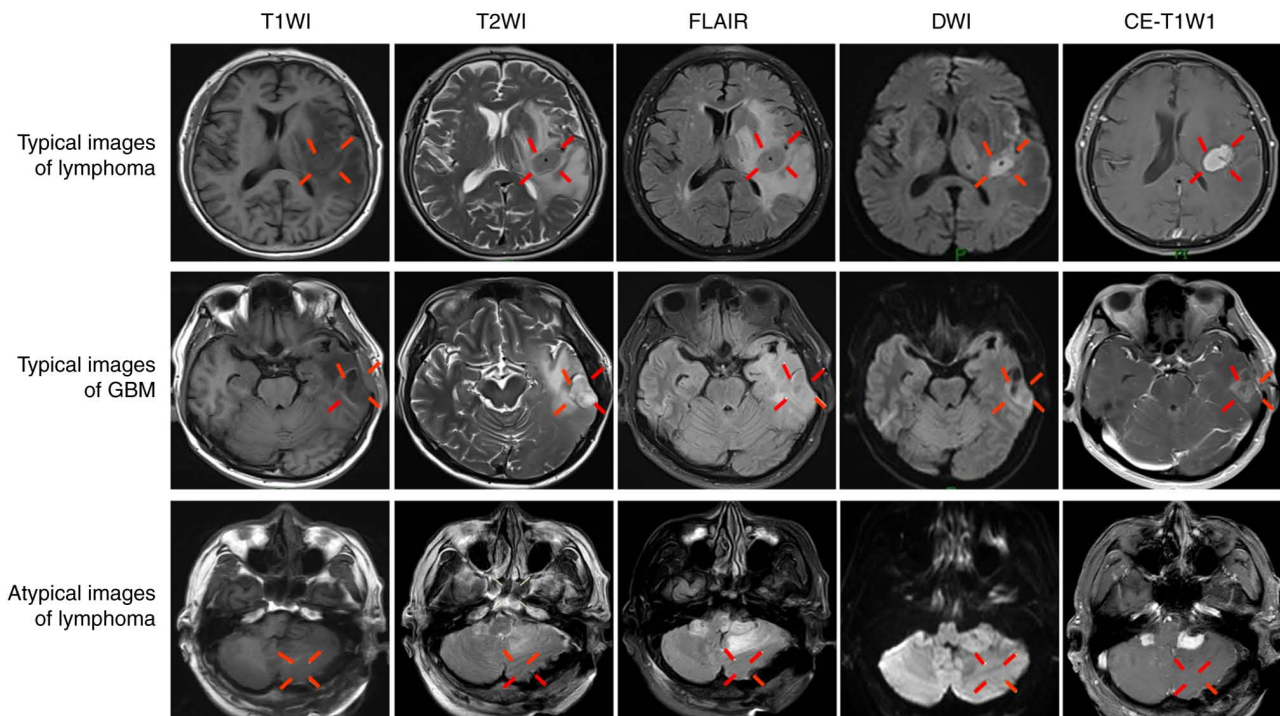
Original magnetic resonance imaging of central nervous system lymphoma or high-grade glioma. Typical images of DLBCL are shown in the top row. The lesion displays as isointense on T1WI and T2WI, as high intensity on FLAIR surrounded by finger-like edema, with limited diffusion on DWI, and with uniform and obvious enhancement on CE-T1WI. Typical images of GBM lesions are shown in the middle row. The lesion displays a low signal on T1WI, a high signal surrounded by finger-like edema on T2WI, as isointense on FLAIR, with no restricted diffusion on DWI, and as garland-like enhancement on CE-T1WI. Atypical images of multiple DLBCL neoplastic lesions are shown in the bottom row. The lesions display as isointense on T1WI and T2WI, as slightly hyperintense on FLAIR with no surrounding edema, with no restricted diffusion on DWI and with obvious uniform enhancement on CE-T1WI. Red lines surround and indicate the lesion in each image. DLBCL, diffuse large B-cell lymphoma; CE-T1WI, contrast-enhanced T1-weighted imaging; FLAIR, fluid-attenuated inversion recovery; DWI, diffusion-weighted imaging; GBM, glioblastoma.
